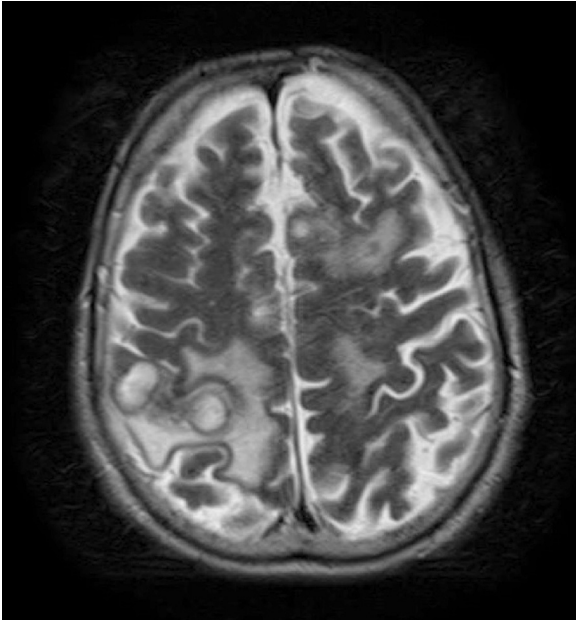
Axial CT scan of the brain with contrast six weeks after initial presentation. There is an interval increase in the number and size of the lesions with surrounding vasogenic edema.
